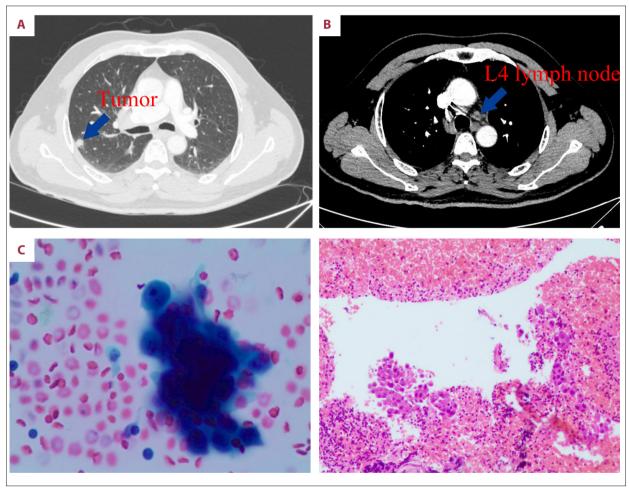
Examinations before treatment. (A) CT scan revealed a solid nodule beneath the pleura in the posterior segment of the right upper lobe with irregular margins. (B) CT scan shows enlarged L4 lymph node in the mediastinum. (C) Left: a few clusters of atypical cells within the blood clot tissue; Right: Metastatic adenocarcinoma cells were found in lymph node (4L).
